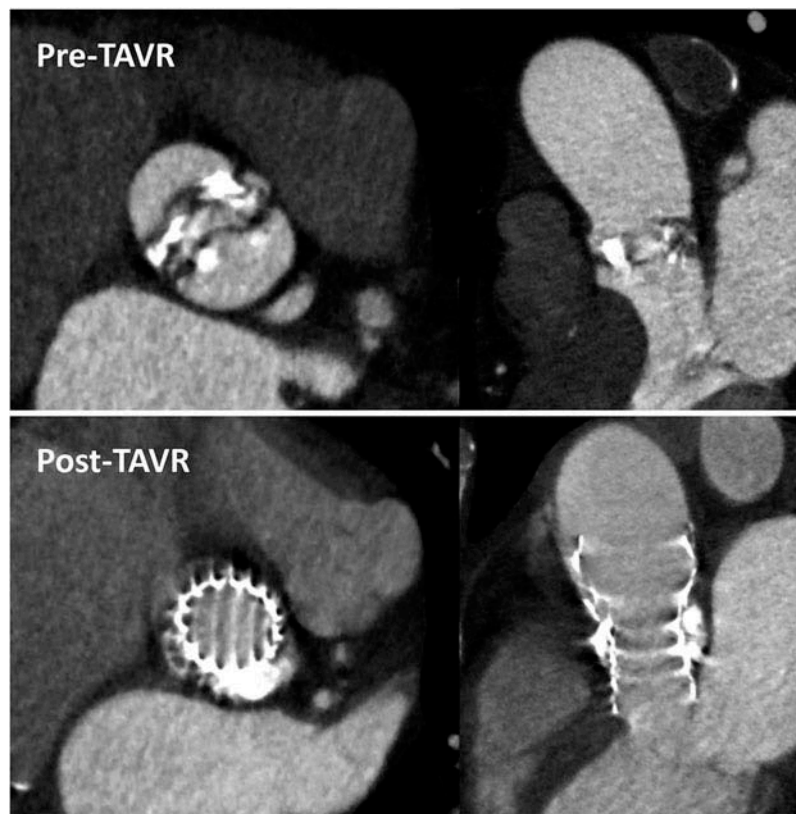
Transcatheter aortic valve replacement in bicuspid aortic valve. Example of type 0 bicuspid aortic valve and heavy calcifications at the edge of the cusps and commissures visualized on the double oblique transversal and sagittal views. After implantation of a CoreValve system, multi-detector row computed tomography shows circular deployment of the transcatheter valve, displacing away the calcifications.
